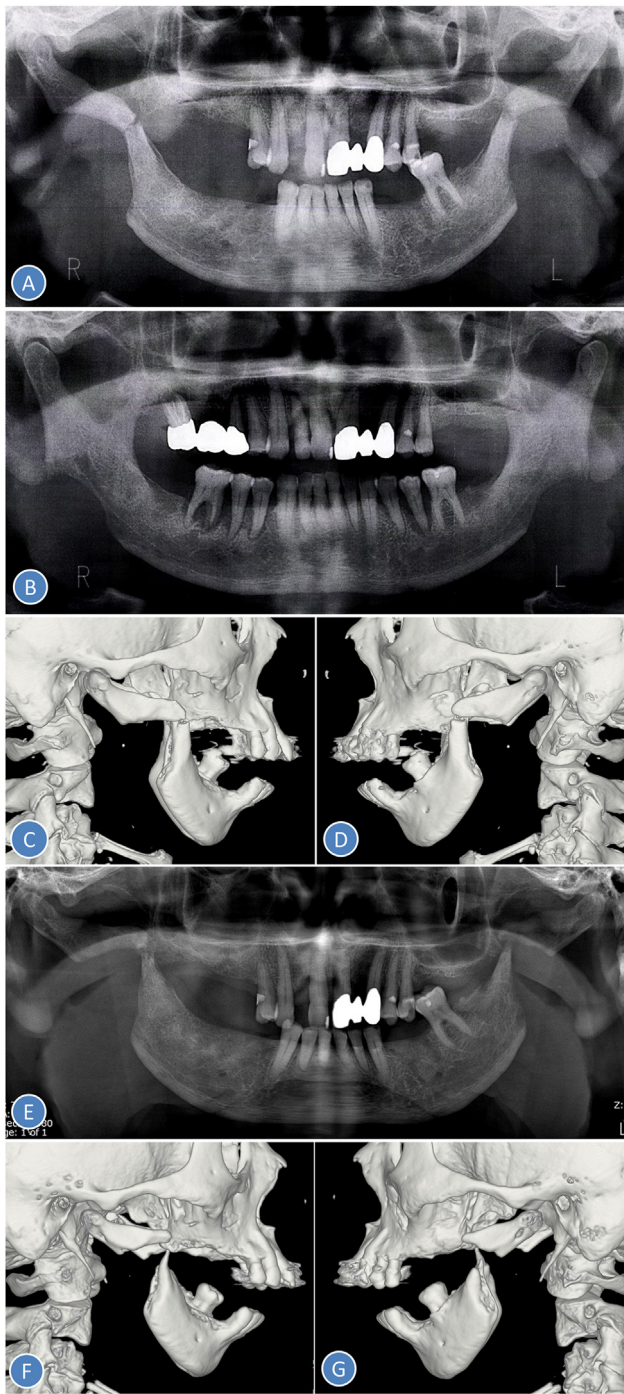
(A) Panoramic radiograph at the initial visit, (B) Panoramic radiograph at 20 months before the initial visit, (C, D) Three-dimensional computed tomography at the initial visit, (E) Panoramic radiograph at 2 months after the initial visit, (F, G) Three-dimensional computed tomography at 6 months after the initial visit.
